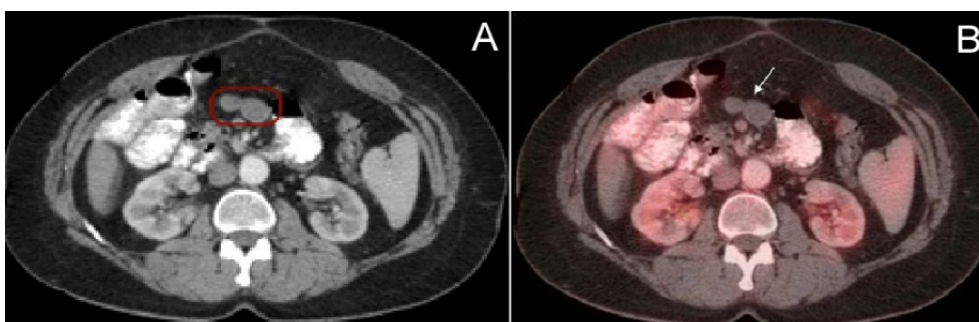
A. Axial CT scan. Centroabdominal image suggestive of mesenteric lymph node metastasis. B. PET/CT-FDG, axial section. Same image without abnormal uptake.
